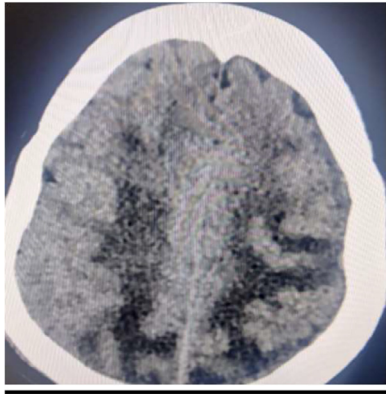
Noncontrast axial CT image at the fronto-parietal lobe region shows hypodensity involving the white matter with finger like extension without obvious mass effect.
